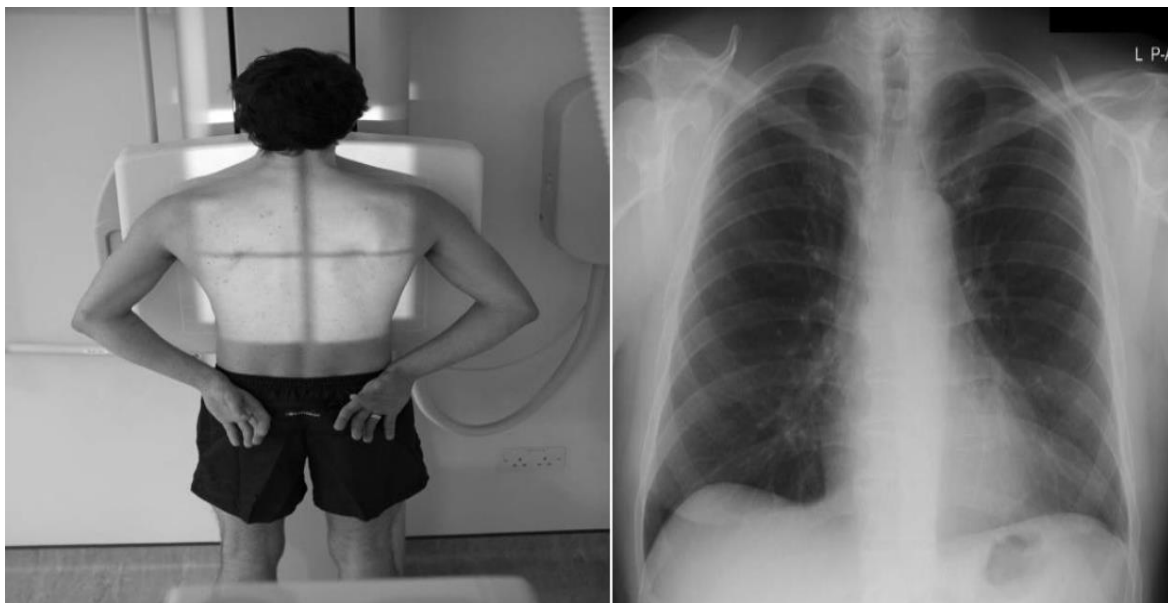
PA radiograph of chest taken using high kV technique.
